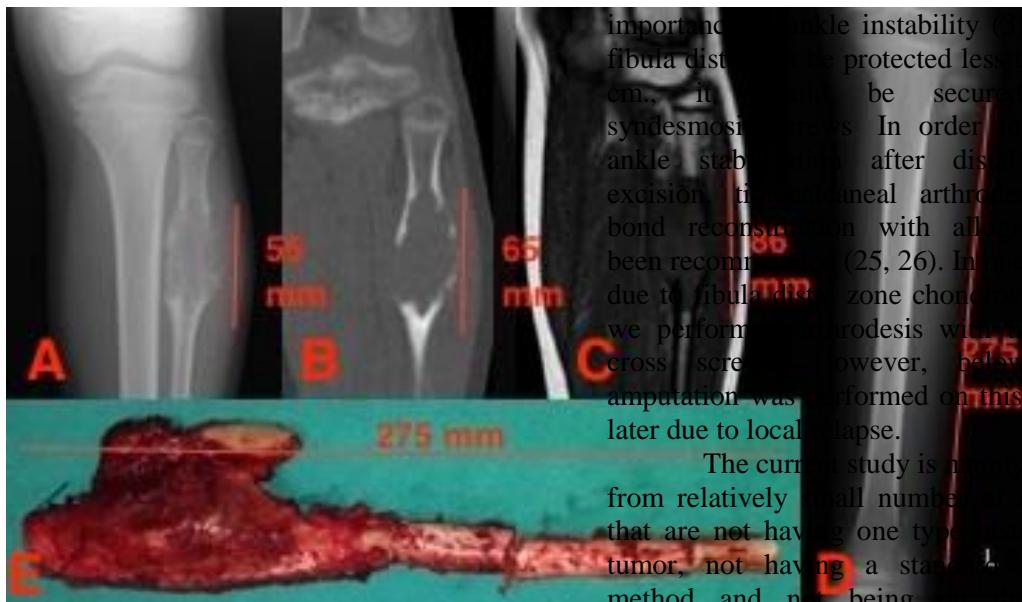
Size of fibula proximal 1/3 located Osteosarcoma. Preoperative imaging A. X-ray, B. CT, C. MRI, Postoperative imaging D. X-ray, E. intraoperative view.
